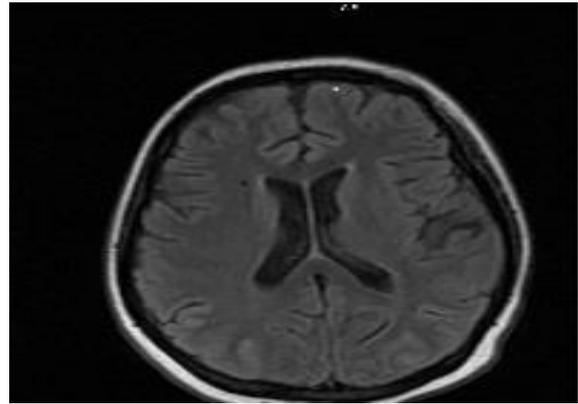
Normal MR imaging findings
